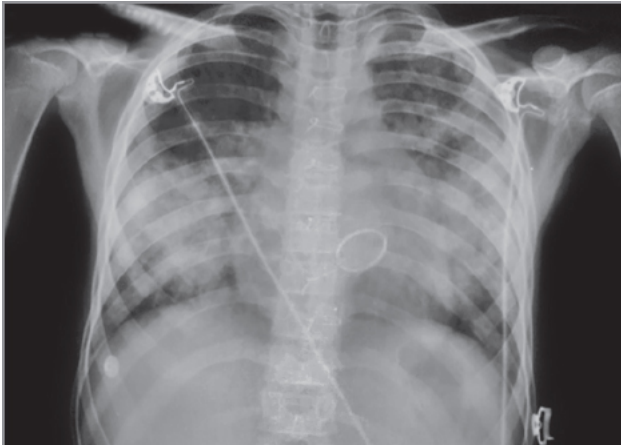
Chest X-ray PA view showing cardiomegaly with bilateral nonhomogeneous opacity in mid and lower zones (bat wing appearance) suggestive of pulmonary edema. Also patient has metallic mitral valve prosthesis.
